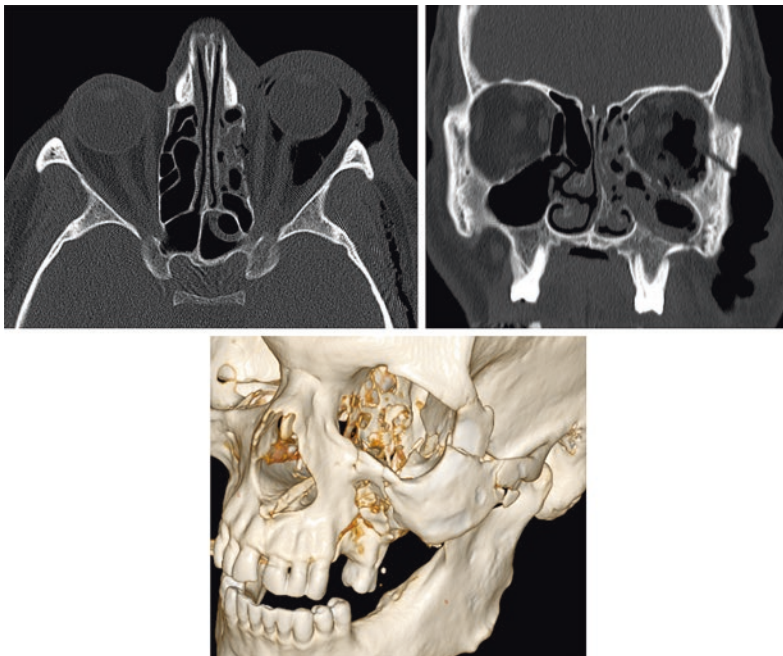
Complex lateral, medial and inferior wall fracture with orbital emphysema. a–c Axial, coronal and 3D reformatted CT images reveal fracture of the medial, inferior and lateral walls of the left orbit associated with orbital and left temporal extracranial emphysema
